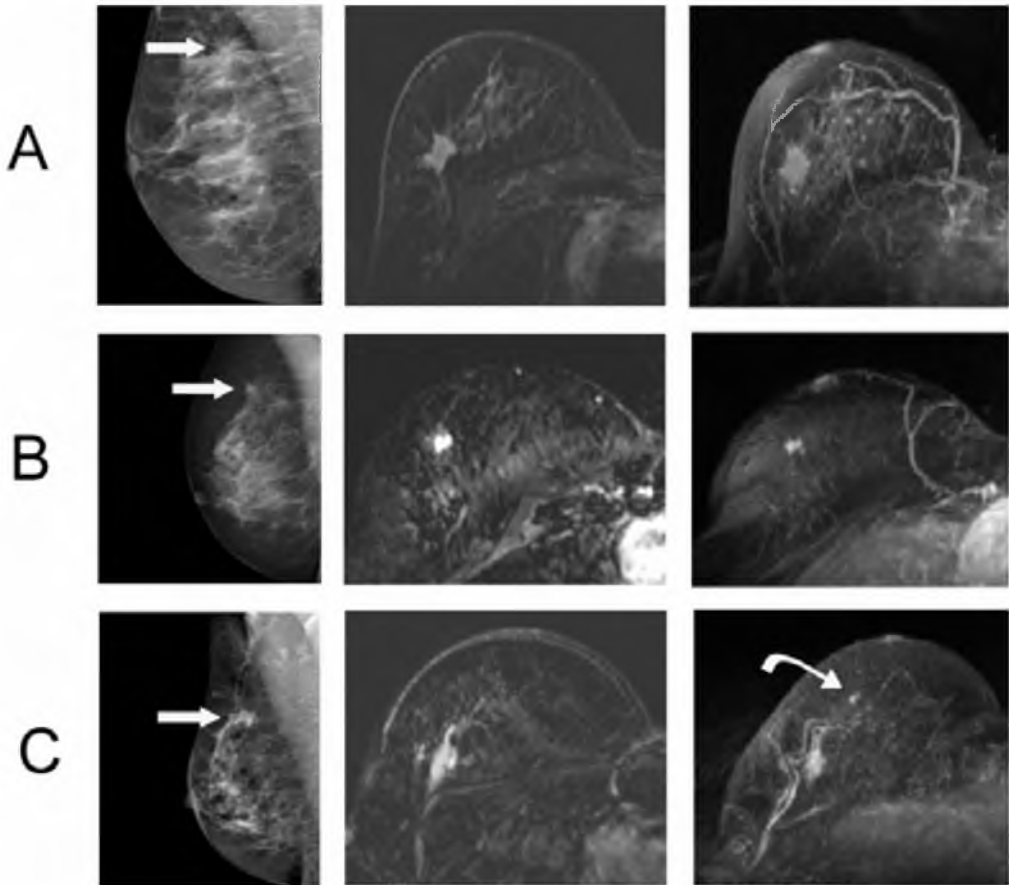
Drie voorbeelden (Rij A, B en C) van massa vormende ILC in de rechter mamma van drie verschillende patiënten op respectievelijk mammografie (eerste kolom), subtractie MRI (tweede kolom) en maximale intensiteitsprojectie van de MRI (derde kolom). De massa's zijn allen irregulair en met name de massa bij A is sterk gespicleerd. Alle massa's waren ook zichtbaar met mammografie (rechte pijlen). Het additionele tumor focus bij patiënt C, meer anterieur gelokaliseerd en op deze plaatjes alleen zichtbaar op de MIP (gebogen pijl) werd echter alleen met MRI gedetecteerd.
